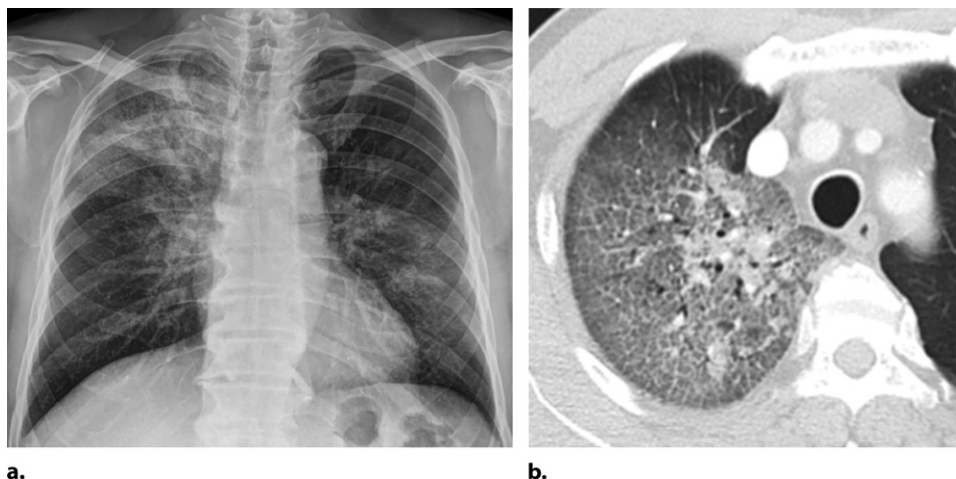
MERS in a 45-year-old man. (a) PA chest radiograph shows right upper lobe and bilateral perihilar heterogeneous and consolidative opacities suspicious for multifocal pneumonia. (b) Axial chest CT image (lung window) focused on the right upper lobe shows subpleural ground-glass opacities and smooth interlobular septal thickening, which result in a crazy-paving pattern.
